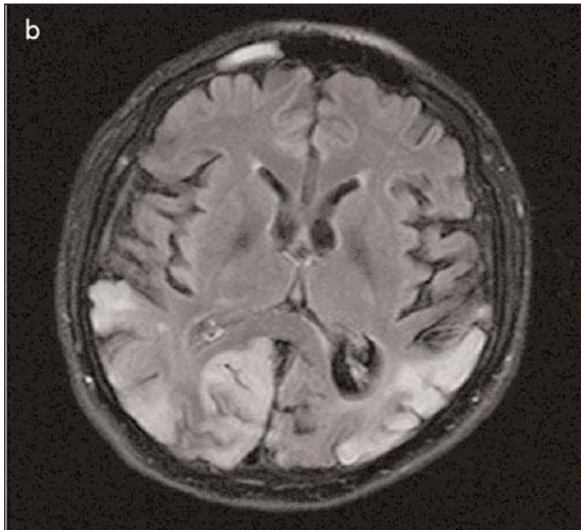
FLAIR images in the brain MRI of the patient with MELAS showed bilateral temporoparietooccipital lesions involving cortical area mostly.
